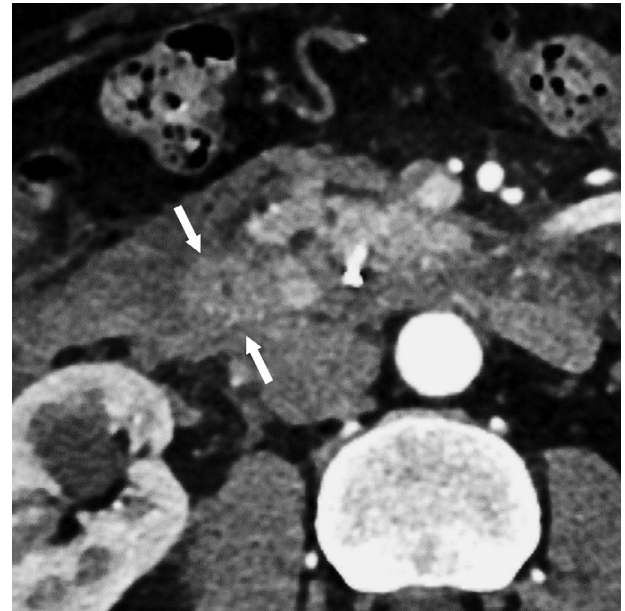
(A) Contrast-enhanced CT shows retroperitoneal hematoma (arrows). (B) Coronal contrast-enhanced CT shows a 4-mm aneurysm on the inferior pancreaticoduodenal artery (IPDA) (arrow). Rupture of an aneurysm of the IPDA is therefore diagnosed.
